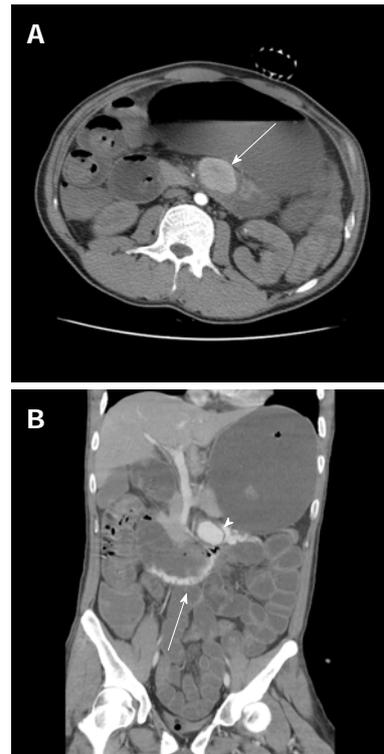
Computed tomography scans. A: Computed tomography (CT) scanning revealed a superior mesenteric artery aneurysm about 3.9 cm in diameter at the jejunal mesentery (white arrow); B: CT scan showing a superior mesenteric artery aneurysm (arrow head) with active contrast extravasation into the fourth portion of the duodenum (white arrow).
